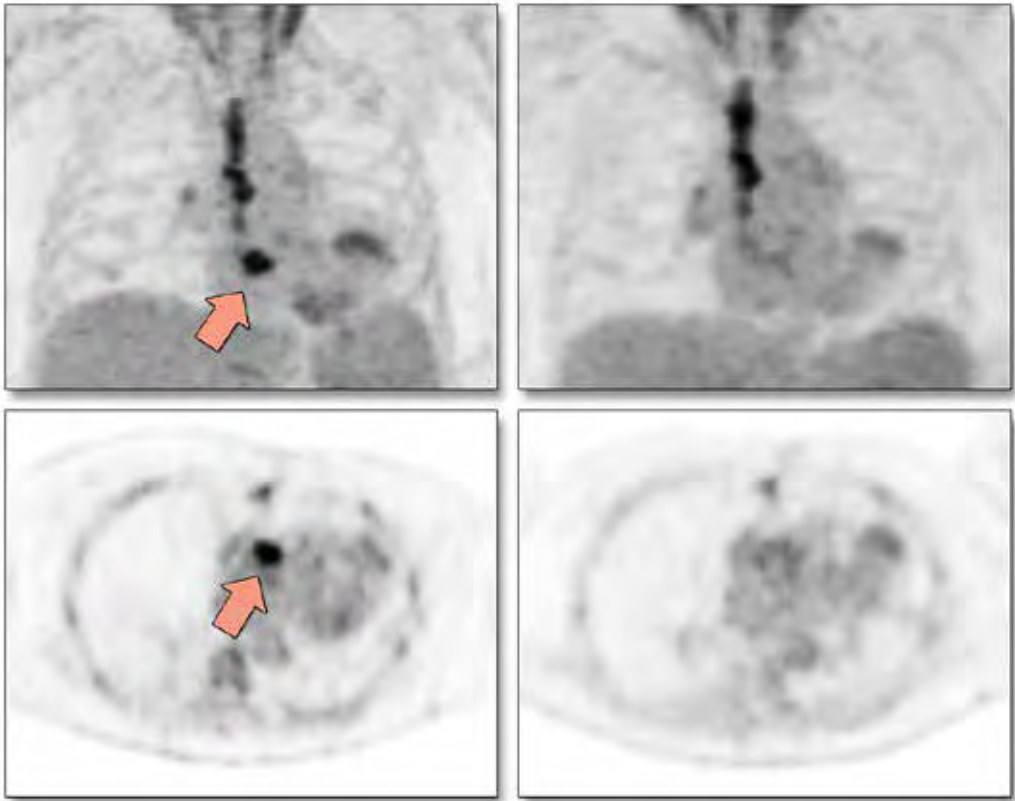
The effect of antibiotic therapy. Maximum intensity projection and transaxial PET images before (left) and during (right) antibiotic therapy in the same patient. The initial scan shows focal activity at the implanted aortic PHV (arrows). At the end of antibiotic therapy, repeat imaging shows only minimal residual ^{18}F -FDG activity around the PHV, suggesting the infection was treated successfully. However, signs and symptoms of infection returned after cessation of antibiotic therapy, with subsequent surgery showing focal persistence of infection. Although the follow-up scan could therefore be argued to be false negative, it is probably true negative with regard to disease activity, as all clinical and laboratory parameters had also normalized. As this case shows, this does not necessarily imply the complete eradication of pathogens as ^{18}F -FDG PET/CT imaging visualizes leukocyte activity rather than the presence of pathogens themselves.
